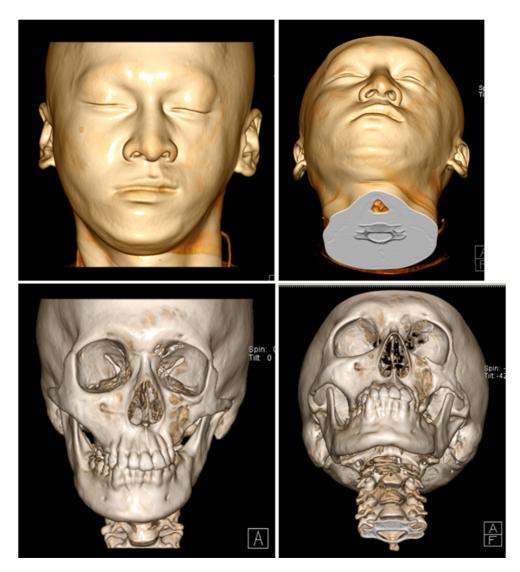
CT scan of facial bone with 3D reconstruction.
